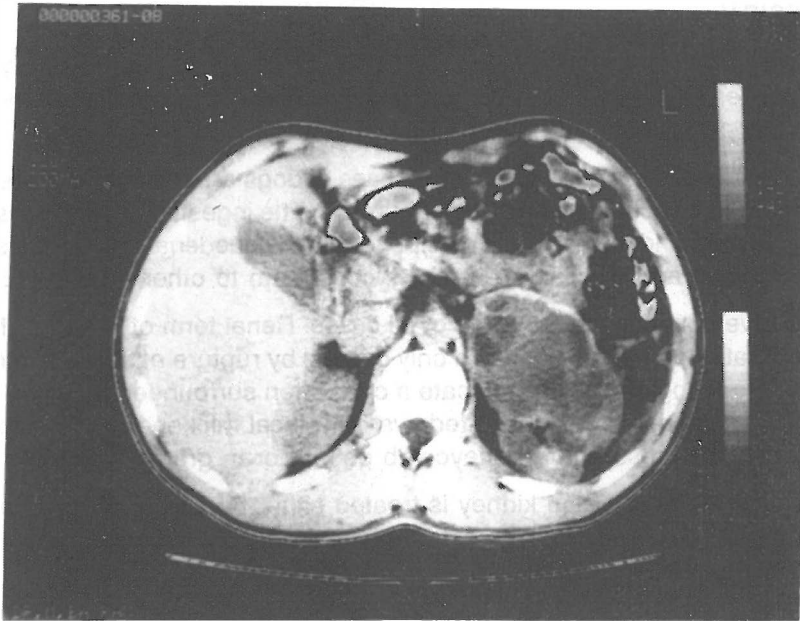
Computed tomography showing multiloculated, cystic appearance of hydatid disease in the left kidney.
